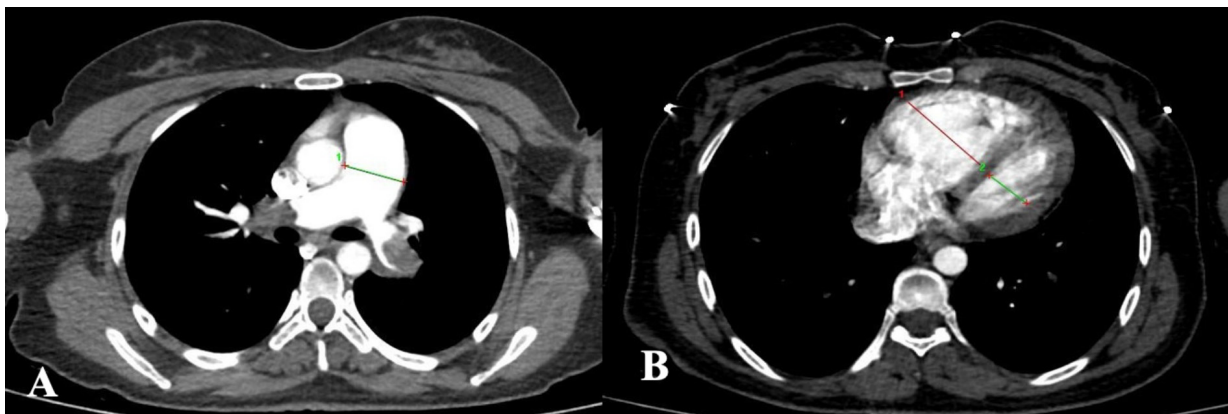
Imaging of the pulmonary artery and determination of ventricular diameters. A, Axial measurement of the main pulmonary artery diameter and images of pulmonary artery obstruction obtained from a computed tomography scan of a sample case. B, Computed tomography pulmonary angiography image of a sample case showing the measurement of the right and left ventricles separately at the valve level from one end to the other end of the inner surface of the ventricular walls.
